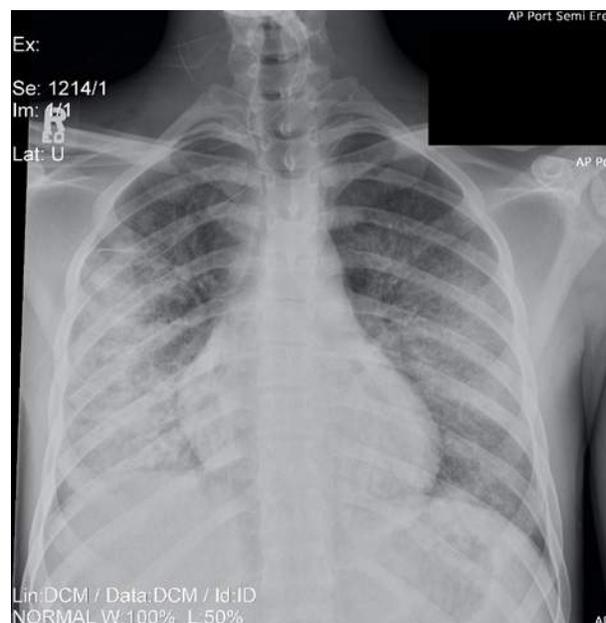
Figure 1. Chest X-Ray taken in the Emergency Department on initial patient presentation.
